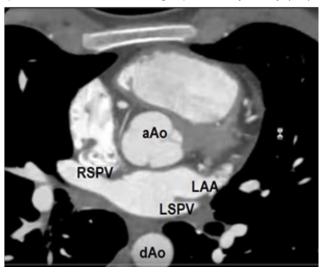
Computed tomography of the heart. The image shows both superior pulmonary veins that can be found in the same plan with the left atrial appendage and the ascending aorta. LAA is trabeculated therefore the contrast cannot completely fill the LAA in its distal portion.
